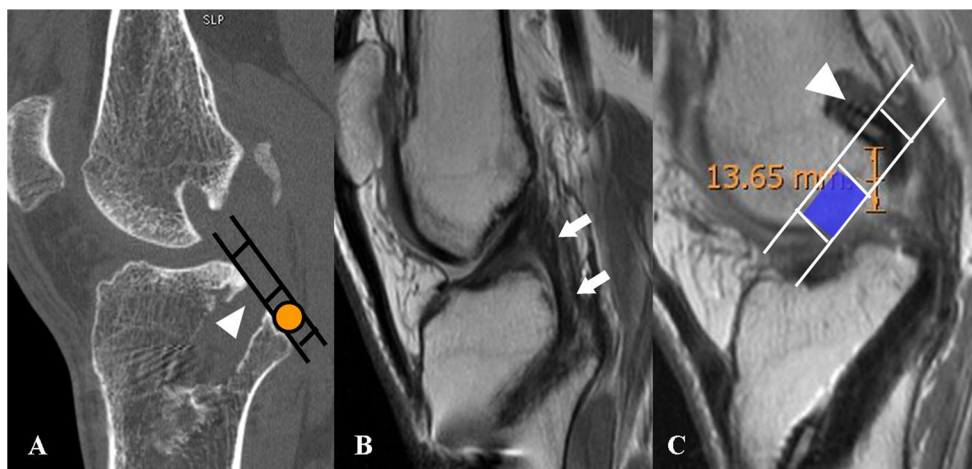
Examples of incorrect tunnel positioning. a–b Excessively proximal position of the tibial tunnel in a patient with instability. a Sagittal MDCT image shows high articular opening of the tibial tunnel (*arrowhead*) in the central region of the retrospinal line. Note the optimal position (*orange circle*). b Sagittal PD MRI shows a PCL graft with a very
